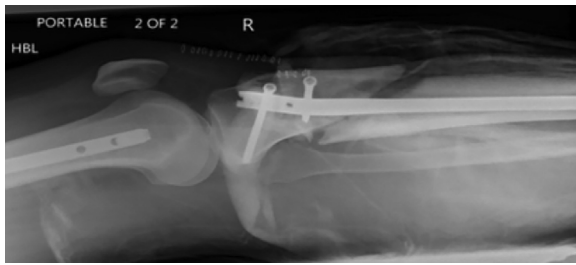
Radiograph of a proximal tibial fracture, fixed with an IMN through an infra-patellar approach, with a residual apex anterior flexion deformity.
